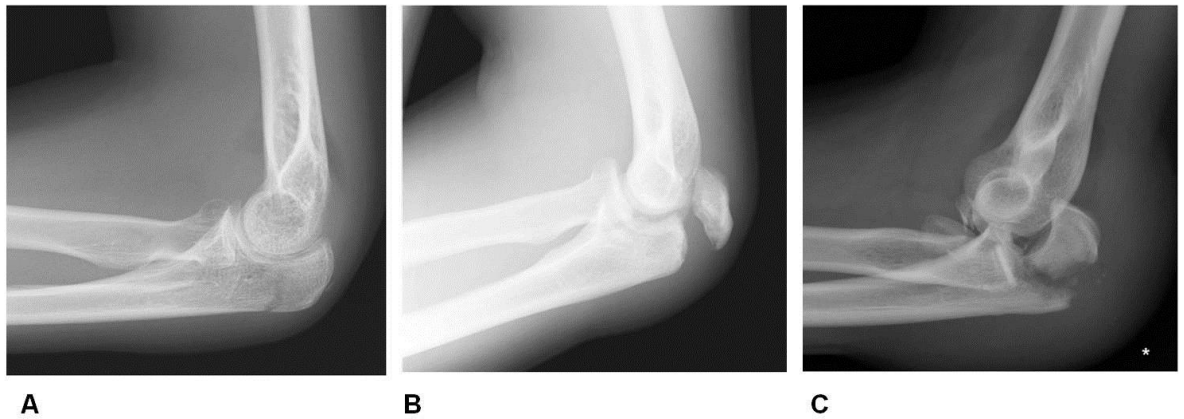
Lateral radiographic examples of Mayo type 1 (A), type 2 (B) and type 3 (C) fractures.
